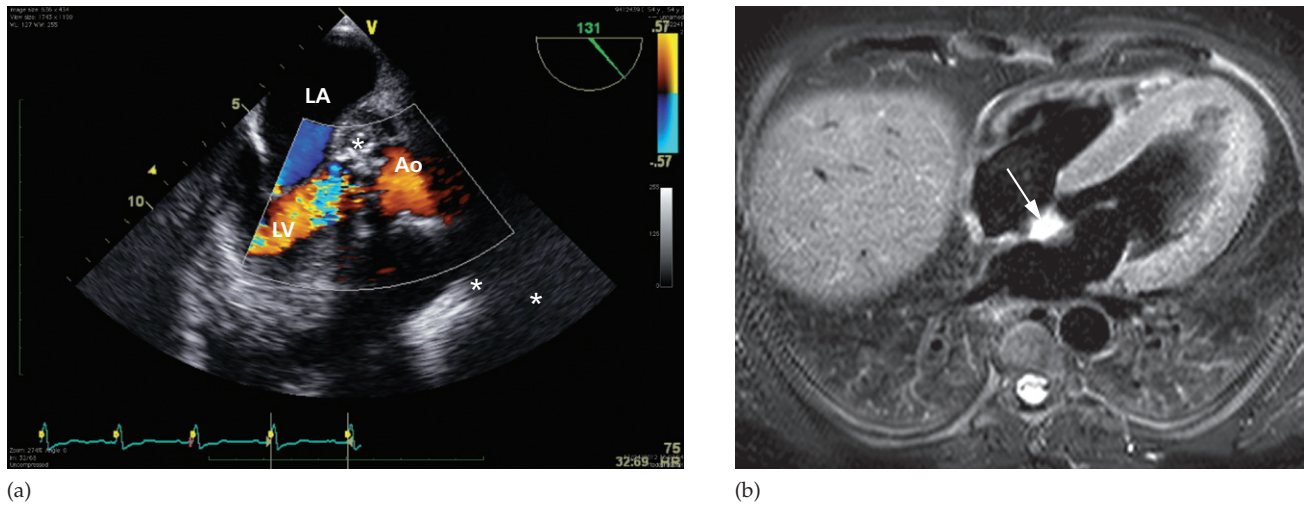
Periaortic root abscess. (a) Transoesophageal echocardiogram (TOE) with Doppler showing a nearly 3 cm hyperechoic mass (*) adjacent to the aorta (Ao). Note that the mass is bulging into the left atrium (LA). LV, left ventricle. (b) T2-weighted axial MRI with fat suppression showing hyperintensity of the periaortic tissue in keeping with an abscess (arrow).
